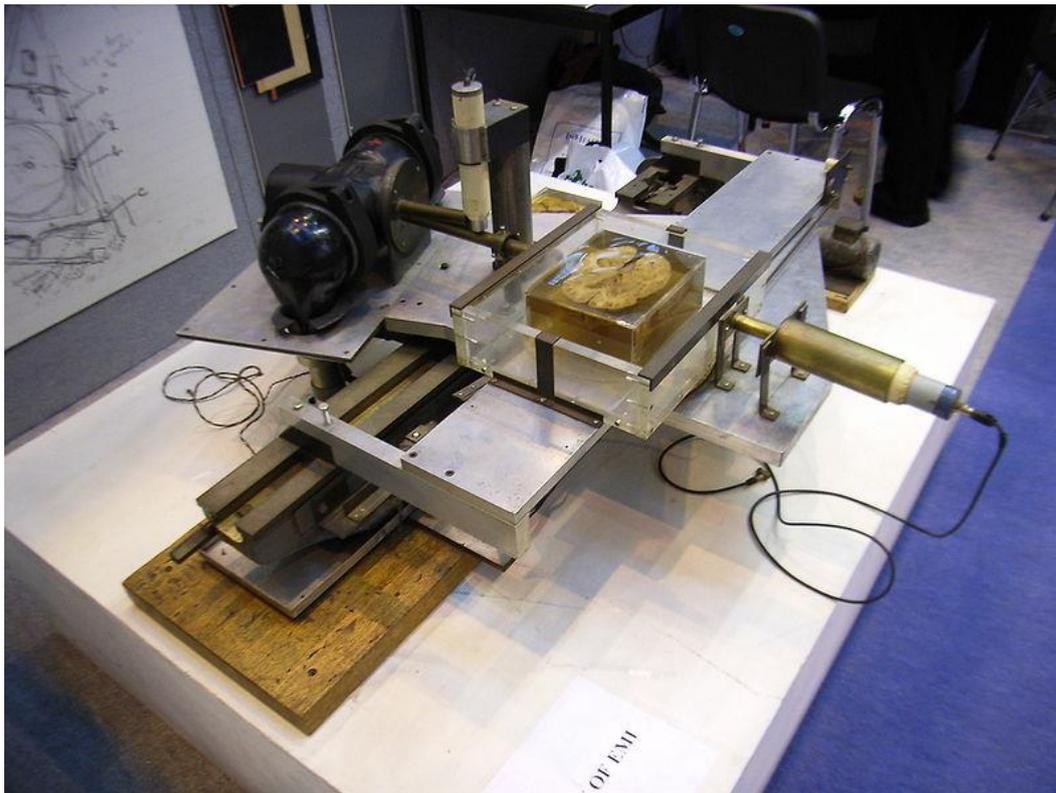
Hounsfield's laboratory device used in the development of the computed tomography method.
